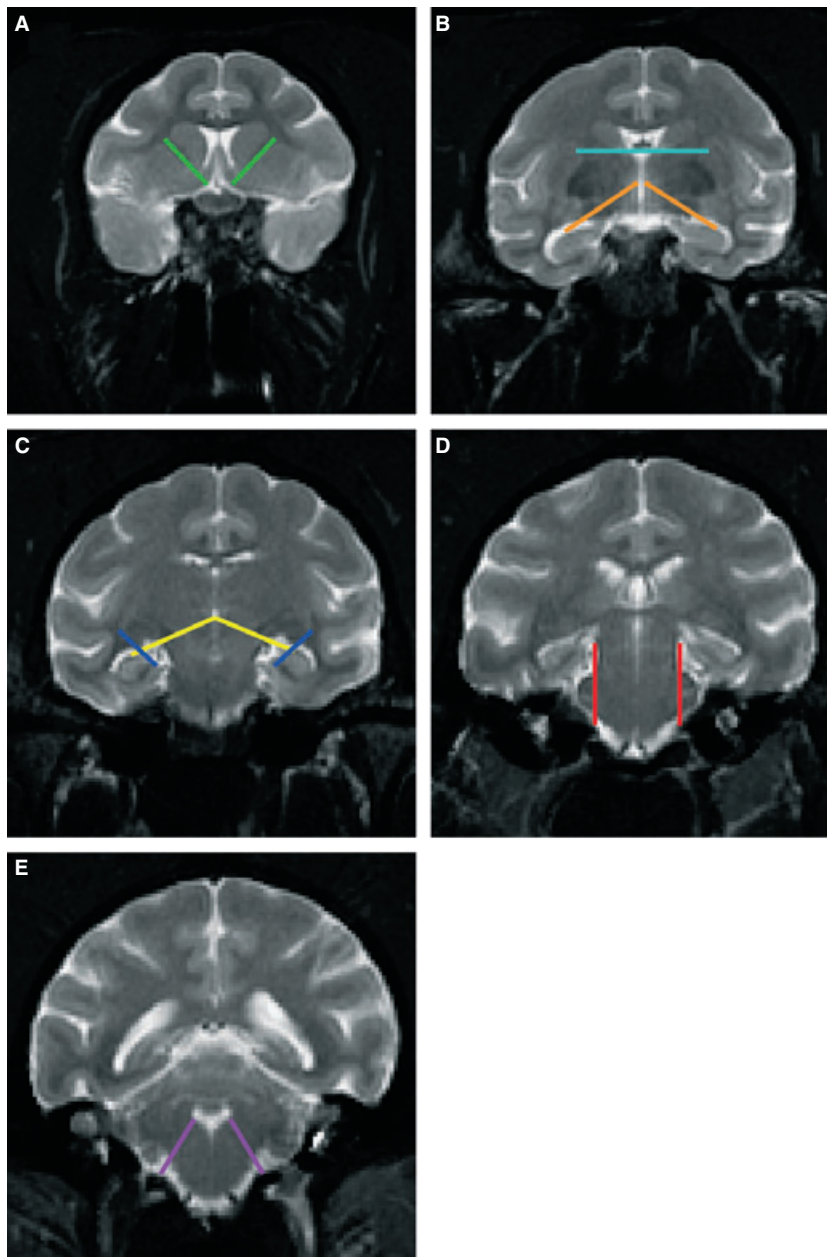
Reference landmarks used to operationally define borders of regions of interest (ROI's). The image slices shown here are representative T2-weighted images of several slices in which the landmark was used by manual raters. Landmarks: caudate-putamen (A, green), third ventricle (B, light blue), thalamus-hypothalamus (B, orange), thalamus-brainstem (C, yellow), lateral ventricle (C, blue), brainstem-cerebellum (D, red), fourth ventricle (E, purple).
